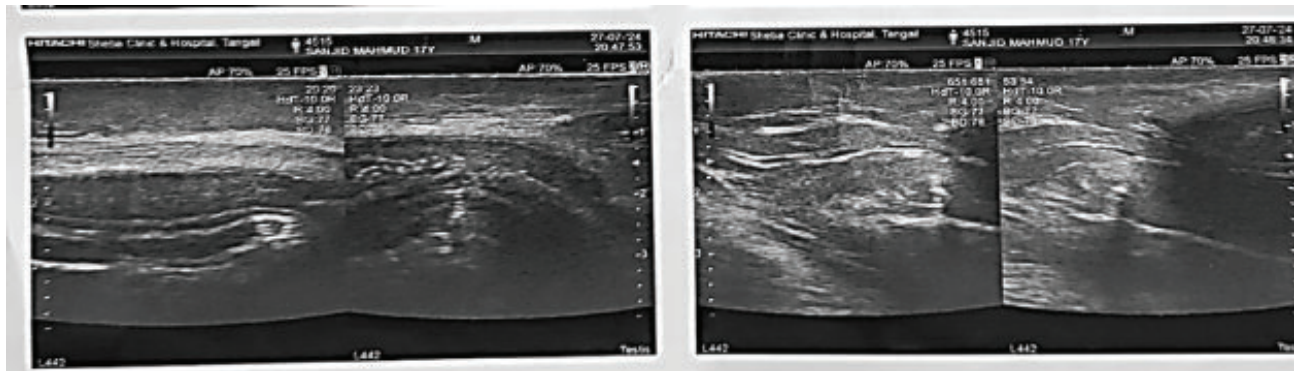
Ultrasound of penis showing tear at tunica albuginea with haematoma formation near root of the penis
